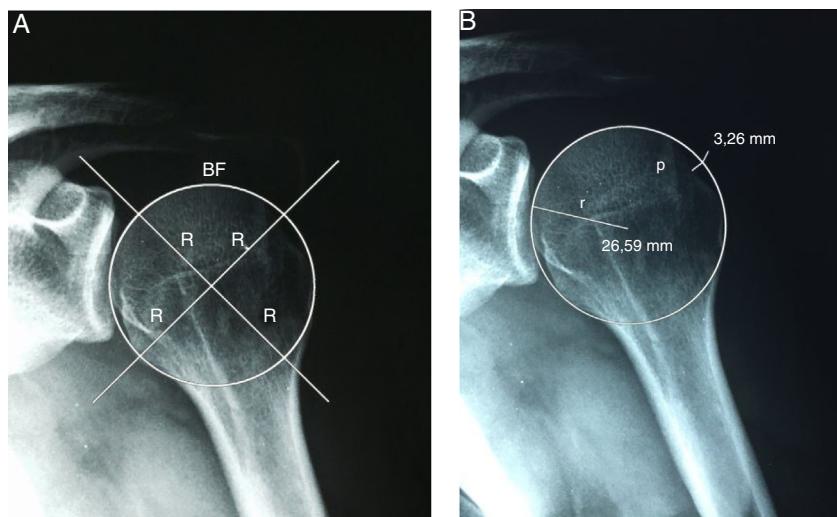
Demonstration of the evaluation of the Hardy index on X-ray. (A) The line around the humeral head represents the best fit (BF). The two perpendicular lines must have radii (R) with the closest possible values between them, thus determining the center of the head. (B) Determination of the humeral head radius (r) and the greatest depth of the HSL defect (p). After the perpendicular lines are removed, the Hardy index is calculated as the ratio of the depth (p) to the radius (r): p/r .
